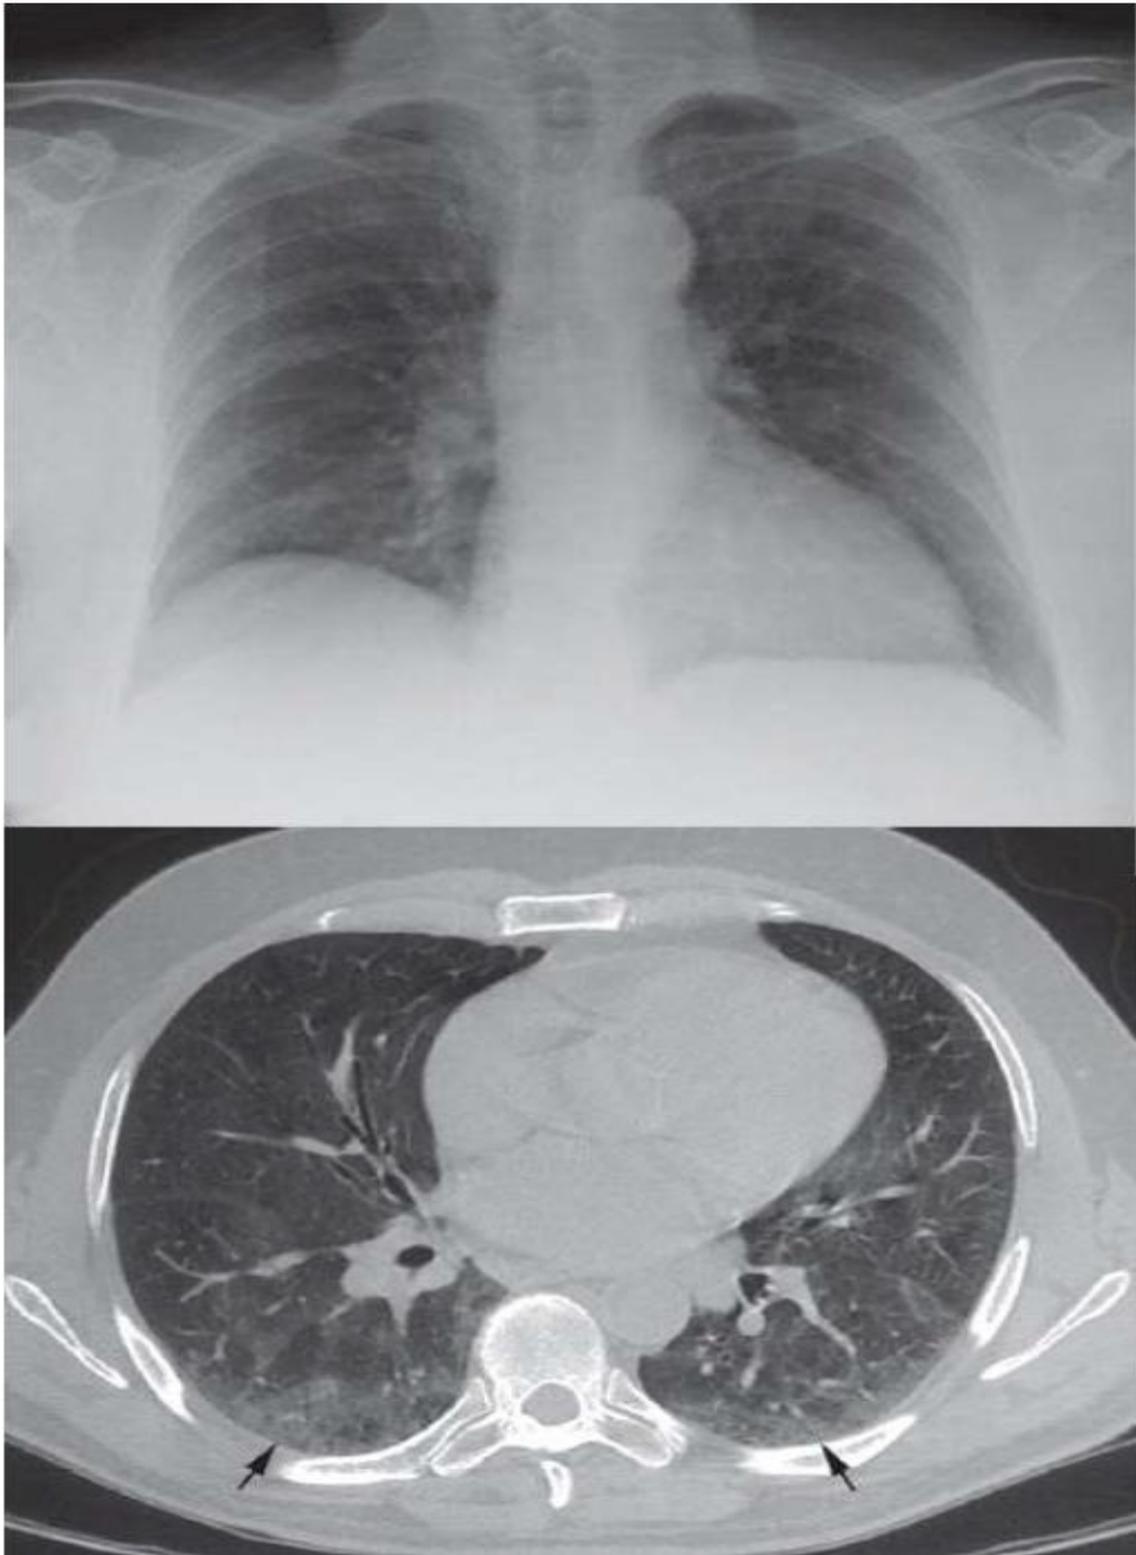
Demonstration of the limited sensitivity of portable chest radiography in the detection of pulmonary infiltrates. A portable chest x-ray of a patient with fever shows no apparent pulmonary infiltrates, while the CT image from the same patient reveals infiltrates in the posterior region of both lungs (indicated by the arrows).
